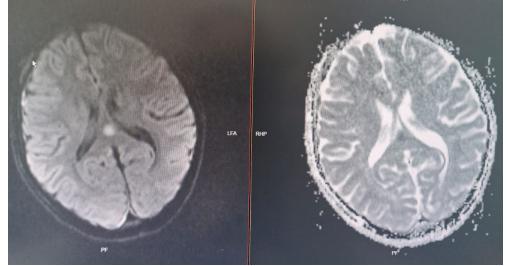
MRI image of the patient
